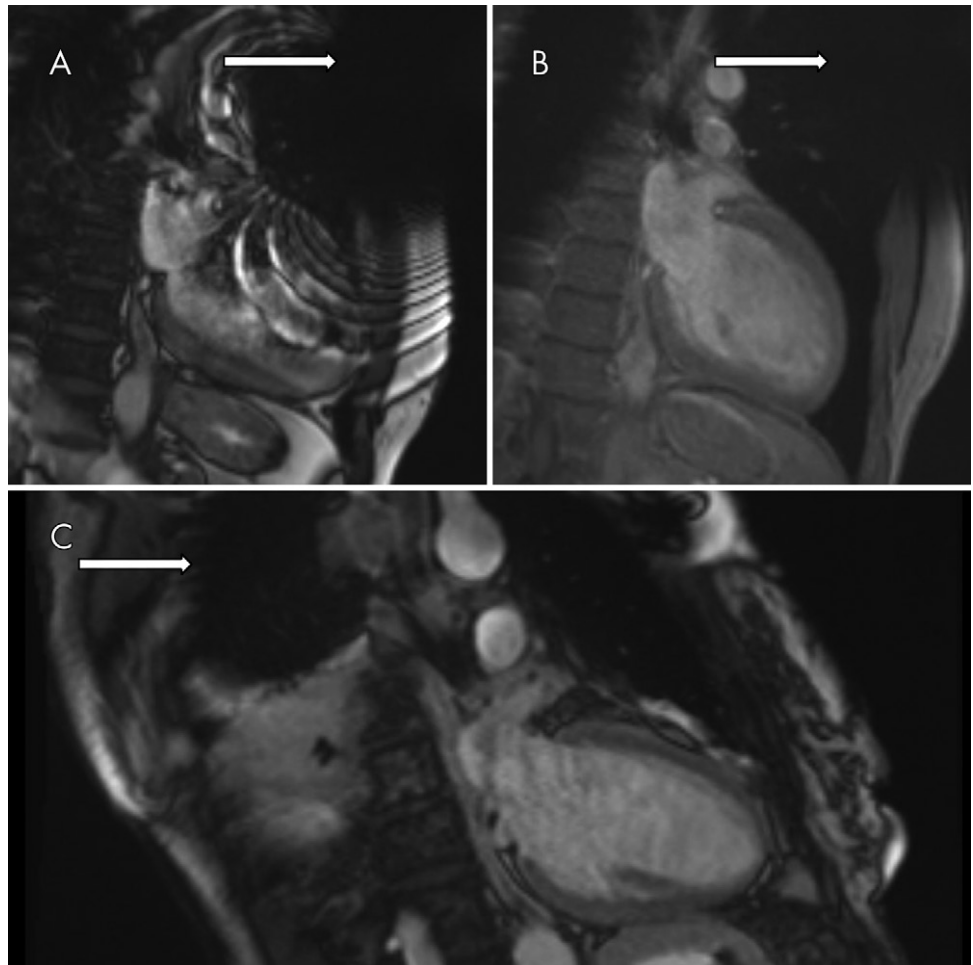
A, B, Images in a 61-year-old man with a Medtronic Evera MRI XT single-chamber implantable cardiac defibrillator. C, Image in a 55-year-old woman with a Medtronic Revo MRI Surescan dual-chamber pacemaker. Images obtained with a Siemens Magnetom Aera 1.5-T unit. Arrows = artifacts caused by an implantable cardiac defibrillator in a two-chamber plane of the left ventricle: A, balanced steady-state free precession sequence with signal loss and banding artifacts, B, gradient-echo sequence (same patient as in A), and, C, balanced steady-state free precession sequence in a right-sided implant, with the generator farther away from the heart.
